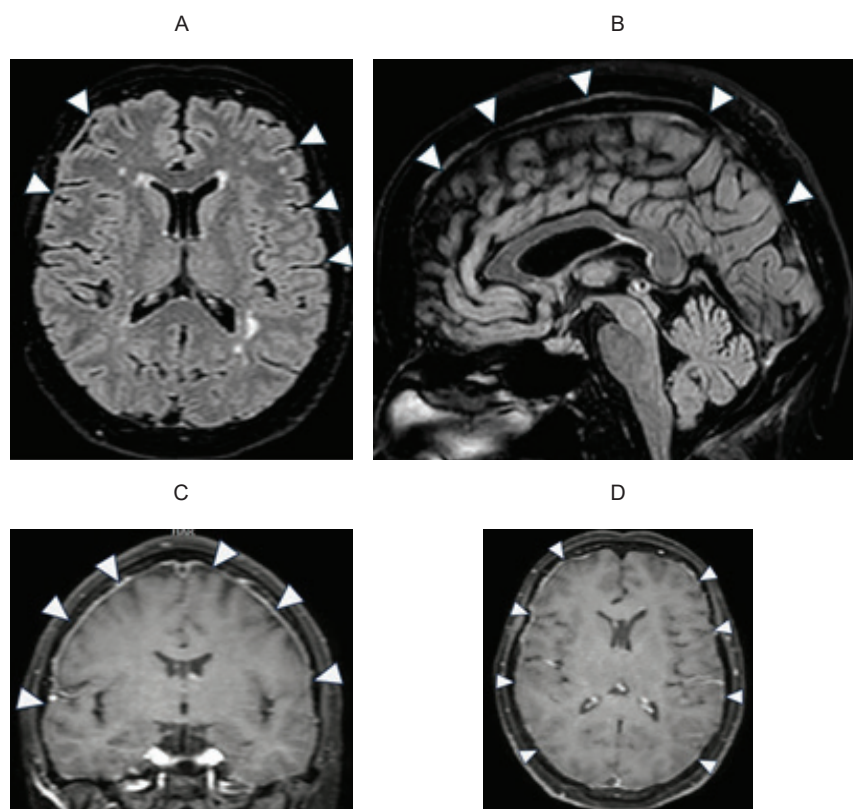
MRI of the brain after steroid therapy: FLAIR images show a decrease in previously identified pachymeningeal enhancement in axial (A) and sagittal (B) sections; paramagnetic accumulation was reduced in coronal (C) and axial (D) sections
